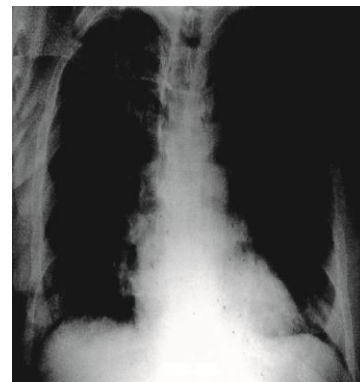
Chest X-ray suggestive of Right Upper Lobe Pneumonia
